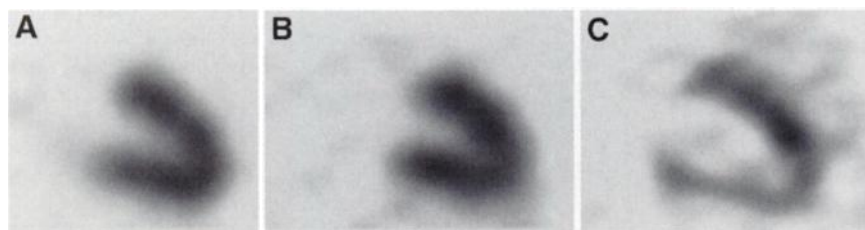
Selected vertical long-axis views of heart of 56-y-old man with normal perfusion (^{99m}Tc -sestamibi) (A) and normal metabolism (FDG) (B) imaged with SPECT camera equipped with high-energy collimator and using DISA protocol. (C) Image of FDG distribution obtained before administration of ^{99m}Tc -sestamibi with dual-head scintillation camera operating in coincidence mode without attenuation demonstrates apparent decrease in metabolism in inferior wall.
